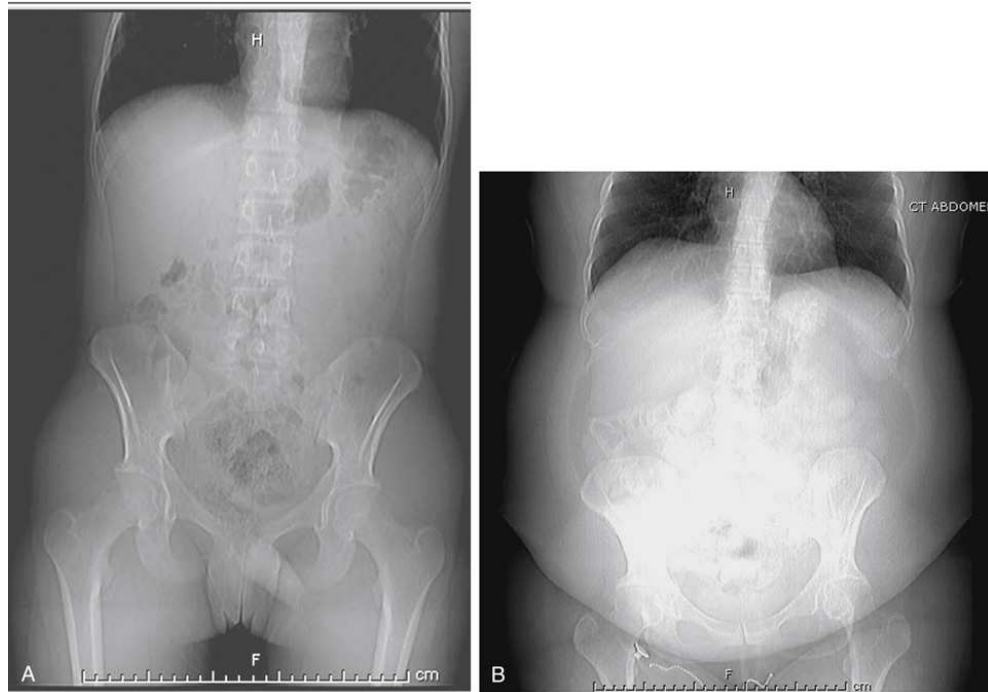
CT abdomen scouts of (A) nonobese patient and (B) obese patient. Note the similar skeletal size and organ locations, although patient B has much greater external dimensions.
